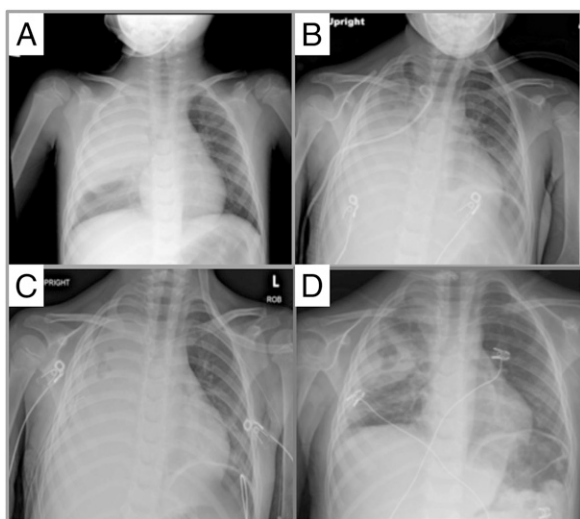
Radiologic progression of complicated pneumonia. A. Radiograph obtained on August 24 shows right upper lobe opacity and small right pleural effusion. B. Radiograph obtained on August 29 shows right middle and lower lobe consolidation and right-sided pleural effusion with chest tube. C. Radiograph obtained on August 30 shows worsening consolidation of the right upper lobe with minimal central lucencies, likely an underlying component of pleural effusion. A chest tube is in place. D. Radiograph obtained on September 3 shows improved aeration with lucencies within the consolidation of the right upper lobe, which suggests cavitation with small right effusion.
